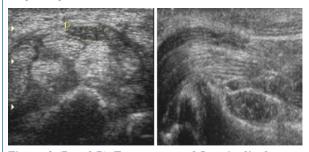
(A and B): Transverse and Longitudinal scans show median nerve incarpal tunnel (A) and 12 mm proximal to wrist (B). There isincrease in cross sectional area of median nerve in carpaltunnel with increased wrist to forearm ratio. In the present study Tendon tear was noted in 03/100 (03 %). Thus HRUSG giving sensitivity and specificity of 66.67 % and 100% respectively. Our result is similar to Wang et al. who used ultrasonic assistance in the diagnosis of flexor tendon injuries and showed that USG was used to make correct preoperative determinations in six of the eight patients they studied.¹⁷
